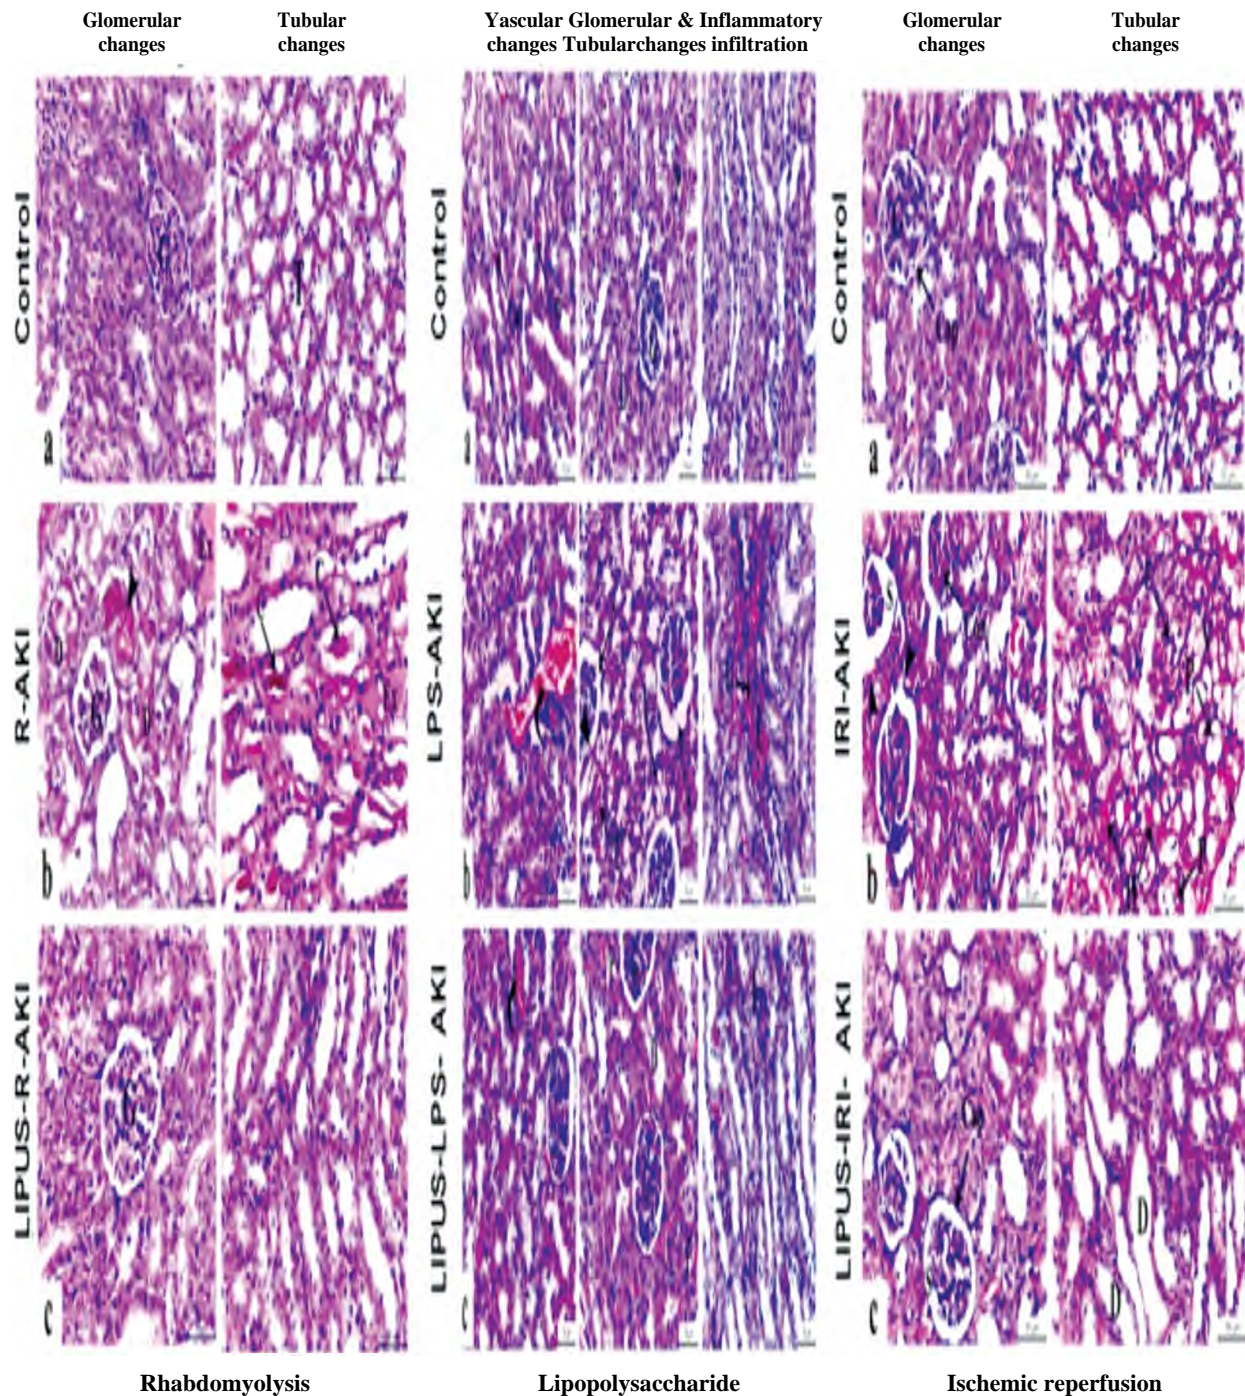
Low-intensity pulsed ultrasound restored the renal structure after AKI.
